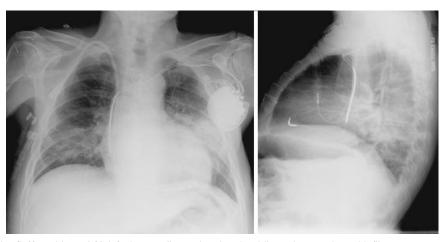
Anterior-posterior (left) and lateral (right) chest radiographs showing bilateral parenchymal infiltrates.
